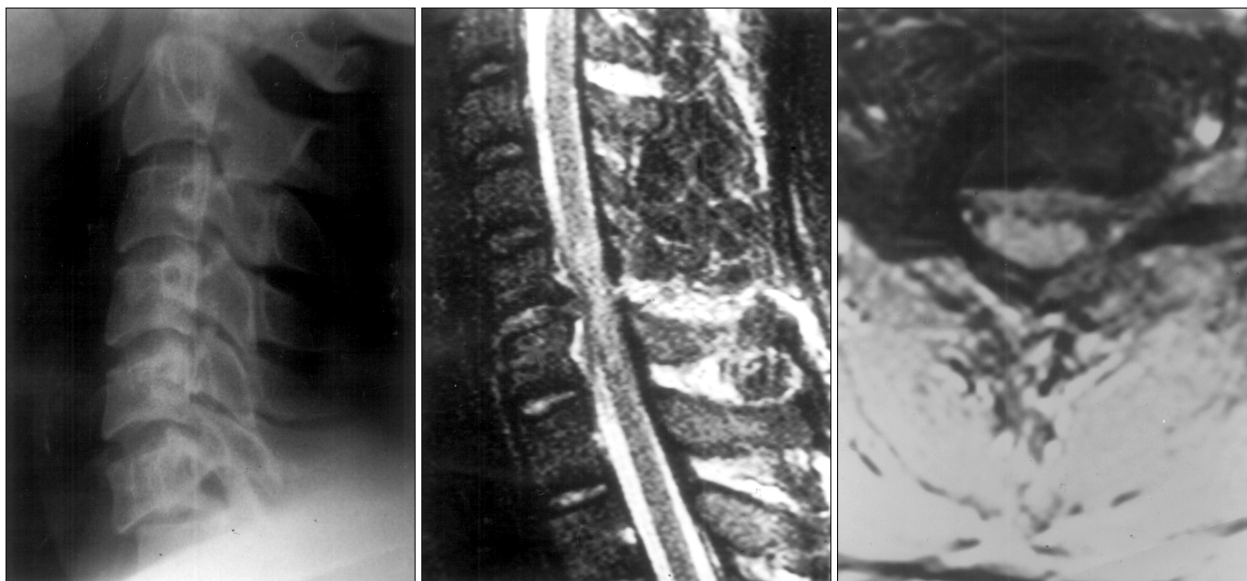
Magnetic resonance images and plain x-ray films obtained in a 30-year-old man with C6/7 flexion injury and Frankel grade C weakness after motor vehicle accident(case 7). Left : preoperative initial plain x-ray film shows C6/7 subluxation by flexion injury. Middle & right : preoperative MR sagittal and axial images revealing ruptured disc particle, which is sharply compressing spinal cord, and posterior interspinous disruption. The patient improved to Frankel Grade D after removal of ruptured disc particle.
